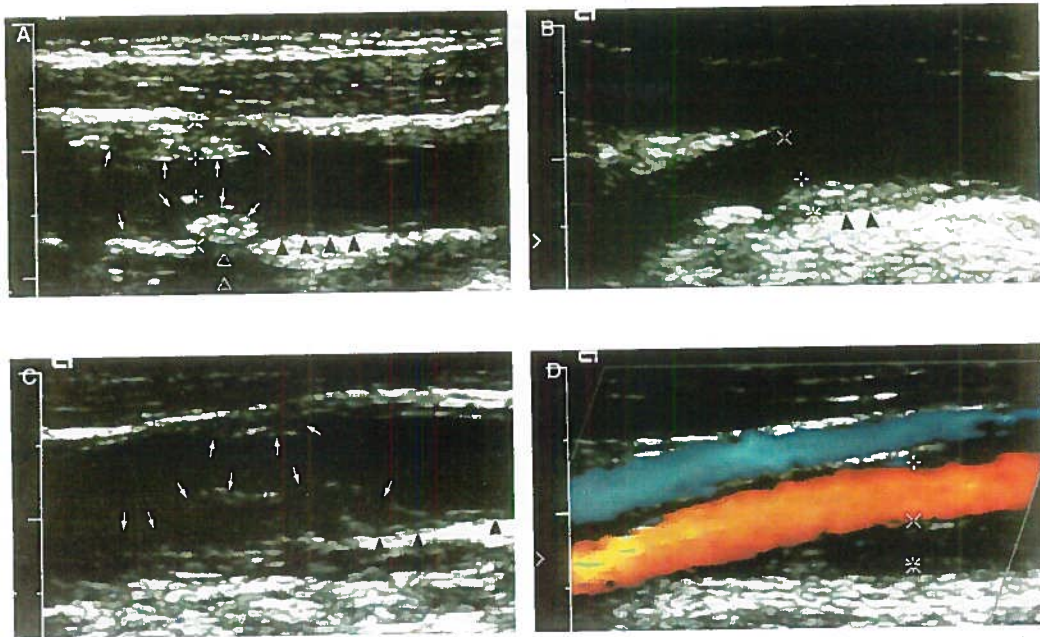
Ultrasound images of carotid atherosclerotic plaques with different echogenicity and heterogeneity. The calipers (+ and x) indicate the artery lumen diameter and plaque thickness. A, Predominantly echogenic (grade 3) and heterogeneous plaque visualized in the near and the far artery walls (white arrows indicate plaque-lumen interface). The far wall plaque is casting an echo shadow (open triangles), hiding the media-adventitia interface underneath. Media-adventitia interface (black arrowheads) to the right of the shadow appears bright and echogenic. B, Predominantly echogenic (grade 3) and homogeneous plaque in the far wall. Media-adventitia interface (black arrowheads) is echogenic. C and D, Images from the same carotid artery (slightly different interrogation angle) showing an echolucent (grade 1) and homogeneous plaque (white arrows) mostly in the far wall, but with a small part of the plaque also visible in the near wall. Color Doppler was used to identify the outlines of echolucent plaques (D).
